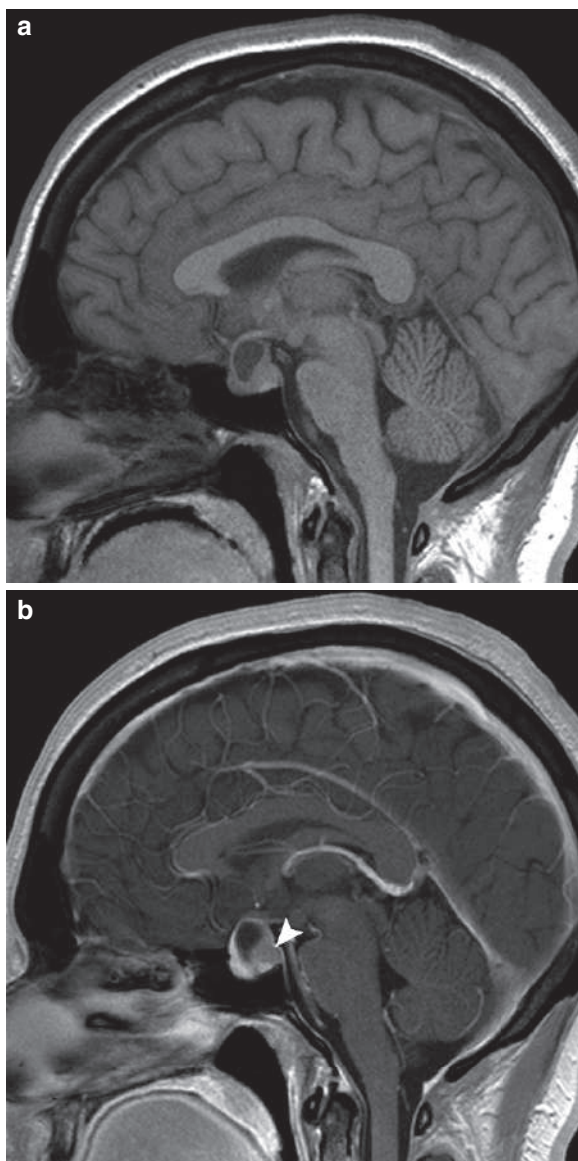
Sagittal T1W (a) and T1Wpostcontrast (b) sella MRI in a patient presented with features of acromegaly. The MR examination showed macroadenoma with cystic changes. The adenoma is detected as a mass with low contrast enhancement (arrowhead) compared with the highly enhanced normal pituitary tissue due to its rich blood supply
